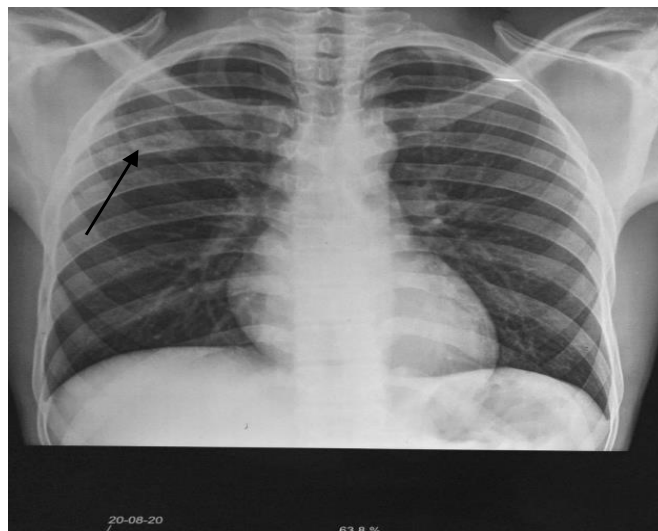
plain Chest radiograph showing a thick walled cavitary lesion in the right upper lung zone (black arrows)
